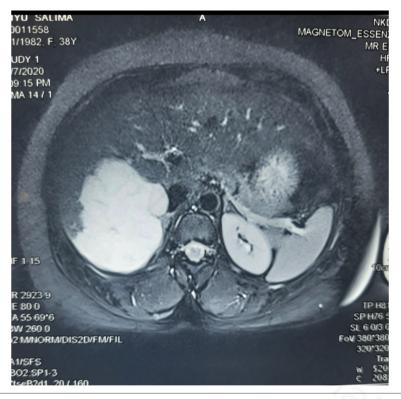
Contrast enhanced MRI Showing the hepatic adenoma.
